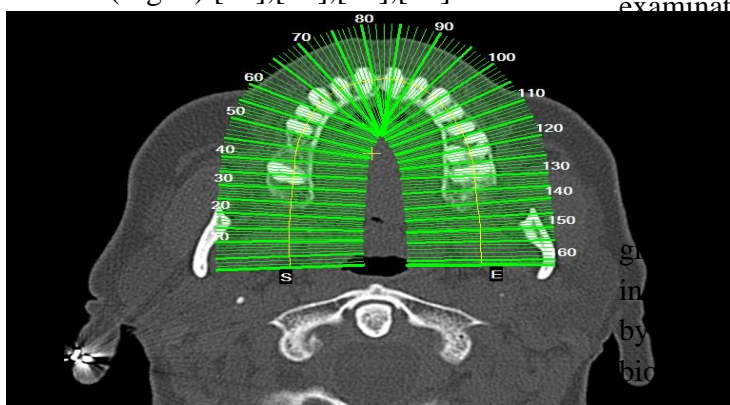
CT-SCAN with the presence of image sections
